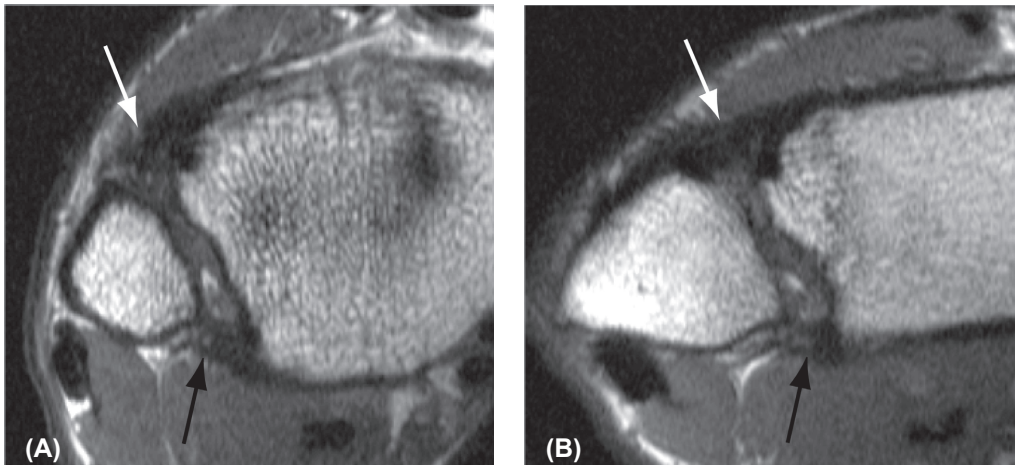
Axial (A) and oblique (B) T1-weighted TSE image of a chronic injury of the ATIFL. The axial image shows a thickened and discontinuous aspect of the ATIFL (white arrow; A). However, in the oblique image the ligament is continuous, although quite thickened (white arrow; B). The two fascicles of the PTIFL are continuous, but slightly thickened in both the axial and oblique planes (black arrow).
